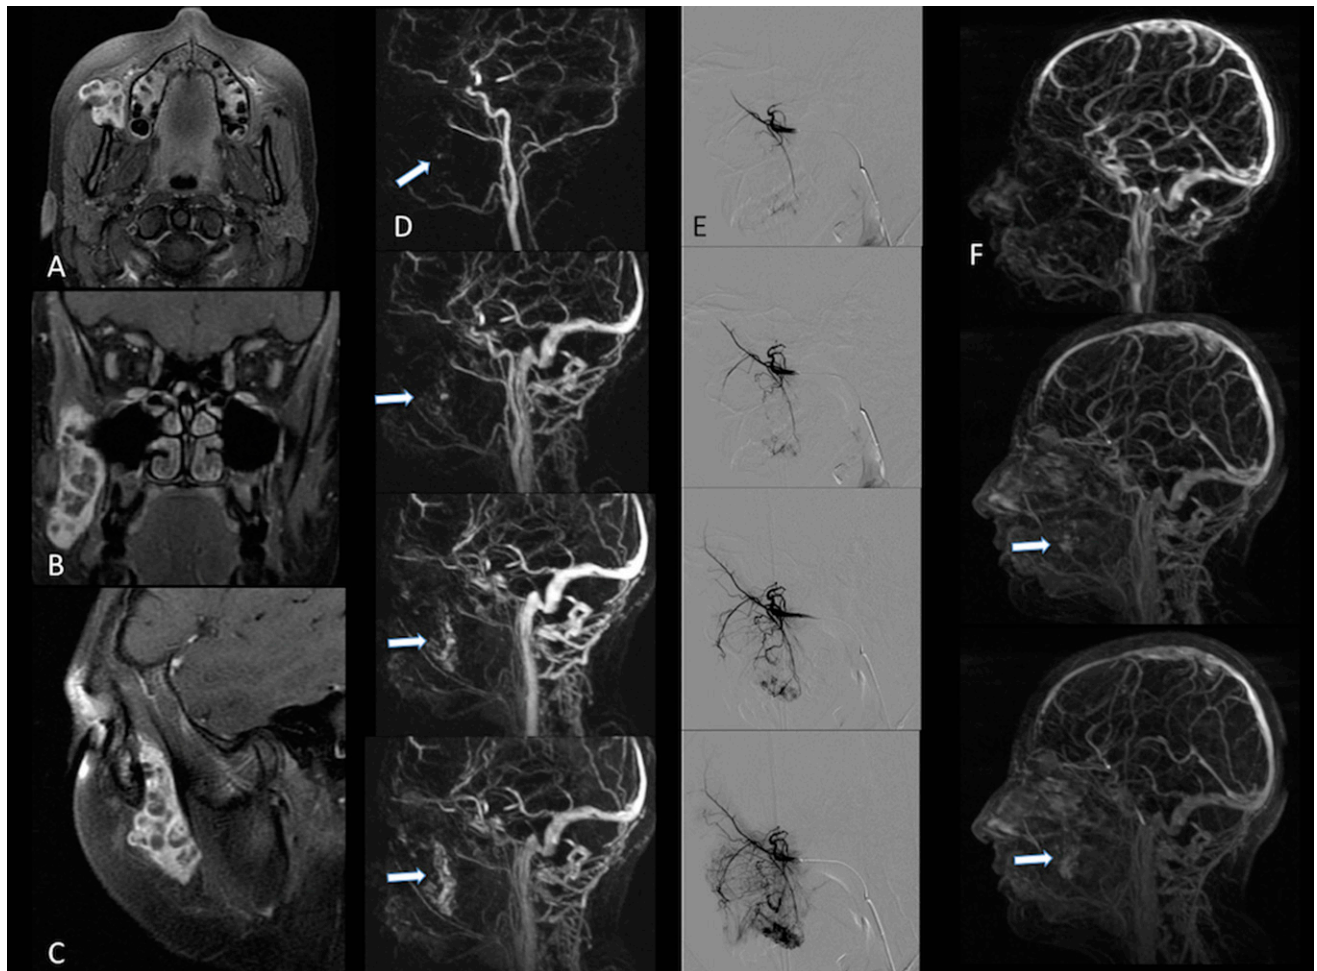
A 15-year-old girl (Patient 1) with tenderness and occasional swelling of the right cheek of about 1 month duration. MRI examination shows a mass lesion close to the anterior margin of the right masseter muscle (a–c). Time-resolved imaging of contrast kinetics (TRICKS) images (d) document a small tissue component with an early arterial enhancement, while the majority of the lesion is characterized by a slow venous enhancement (arrows). Digital subtraction radiography confirms these findings [selected angiogram of internal maxillary artery, (e)]. In TRICKS images after embolization (f), the residual component of haemangioma is evident (arrows).
